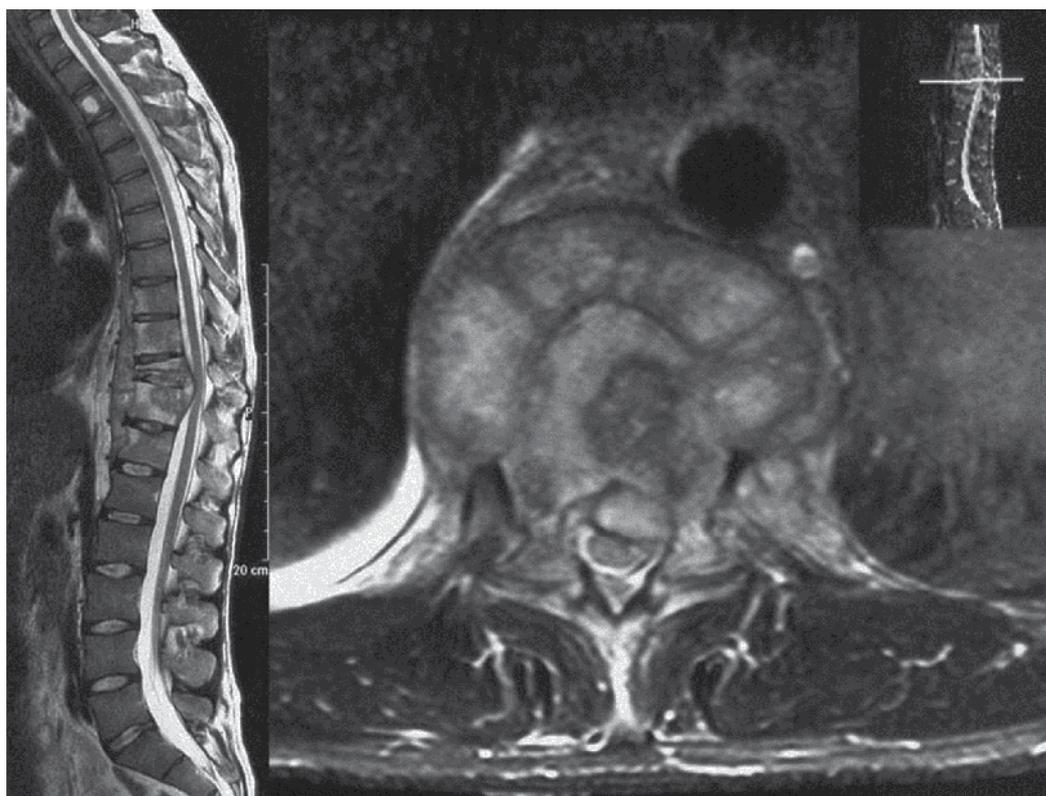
Spondylodiscitis (*Mycobacterium Xenopi*). Sagittal and axial T2-weighted MRI with contrast medium.
